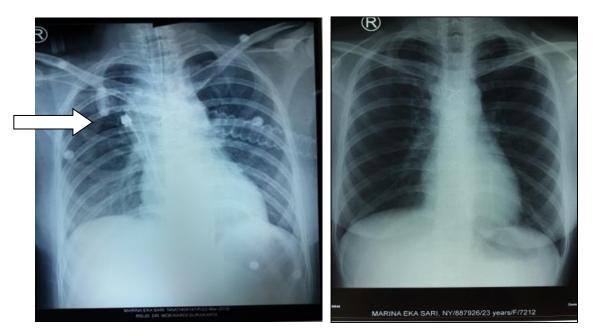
A. Chest X-ray postoperative evaluation in March 2018 it appears that homogeneous opacity in the mediastinum is reduced compared to before surgery. B. Chest X-ray evaluation at the end of the 12th month of anti-tuberculosis drugs, July 4th 2018 the lung is within normal limits
